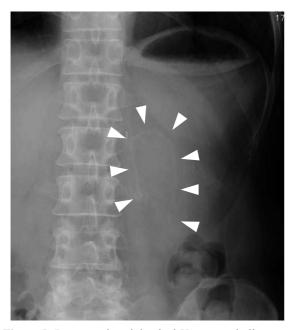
Postoperative abdominal X-ray: staple lines are longer than bisection line in the minor axis direction of the residual stomach (white arrowheads point to staple lines).
